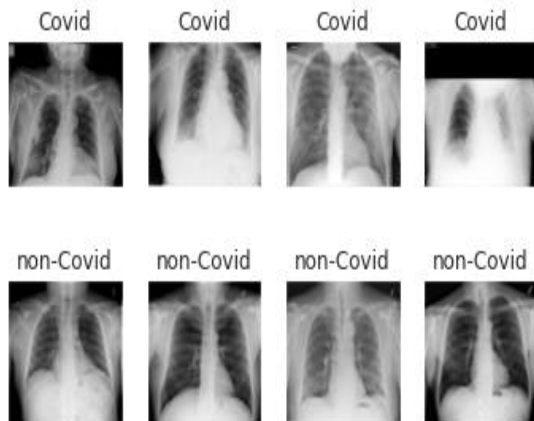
Random images from Xray dataset
